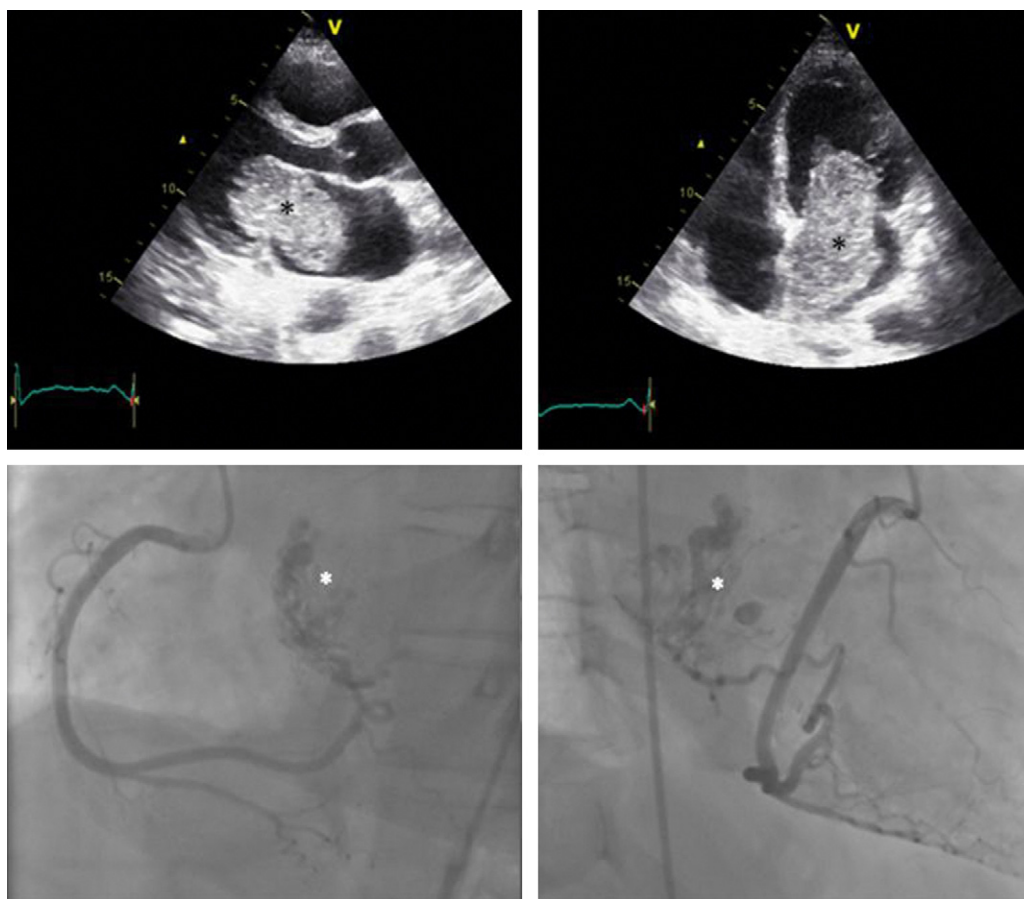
Giant obstructive left atrial myxoma with separate coronary artery branch. Upper left: transthoracic echocardiography end-diastolic still frame of parasternal long-axis view showing the giant left atrial myxoma protruding through the mitral valve (black asterisk). Upper right: transthoracic echocardiography end-diastolic still frame of apical four-chamber view (black asterisk). Below left: coronary angiography image in left anterior oblique view with a large posterolateral branch of the right coronary artery vascularizing the myxoma with a large distinct vascular network (white asterisk). Below right: coronary angiography image in right anterior oblique view (white asterisk).
